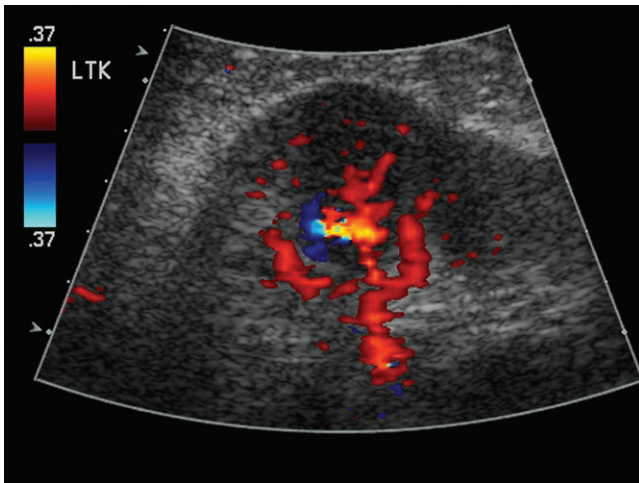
Color Doppler through that region demonstrating similar Doppler appearance between that region and the rest of the kidney. There is no displacement of vessels.
